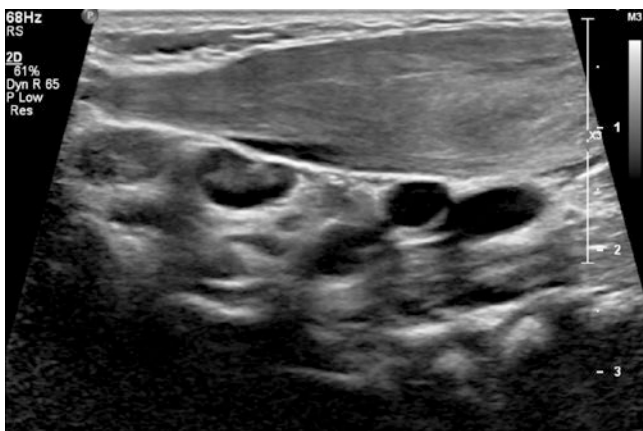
Left-sided fibromatosis colli. Longitudinal ultrasound image shows the upper (cranial) end of the swelling in continuity with normal muscle
